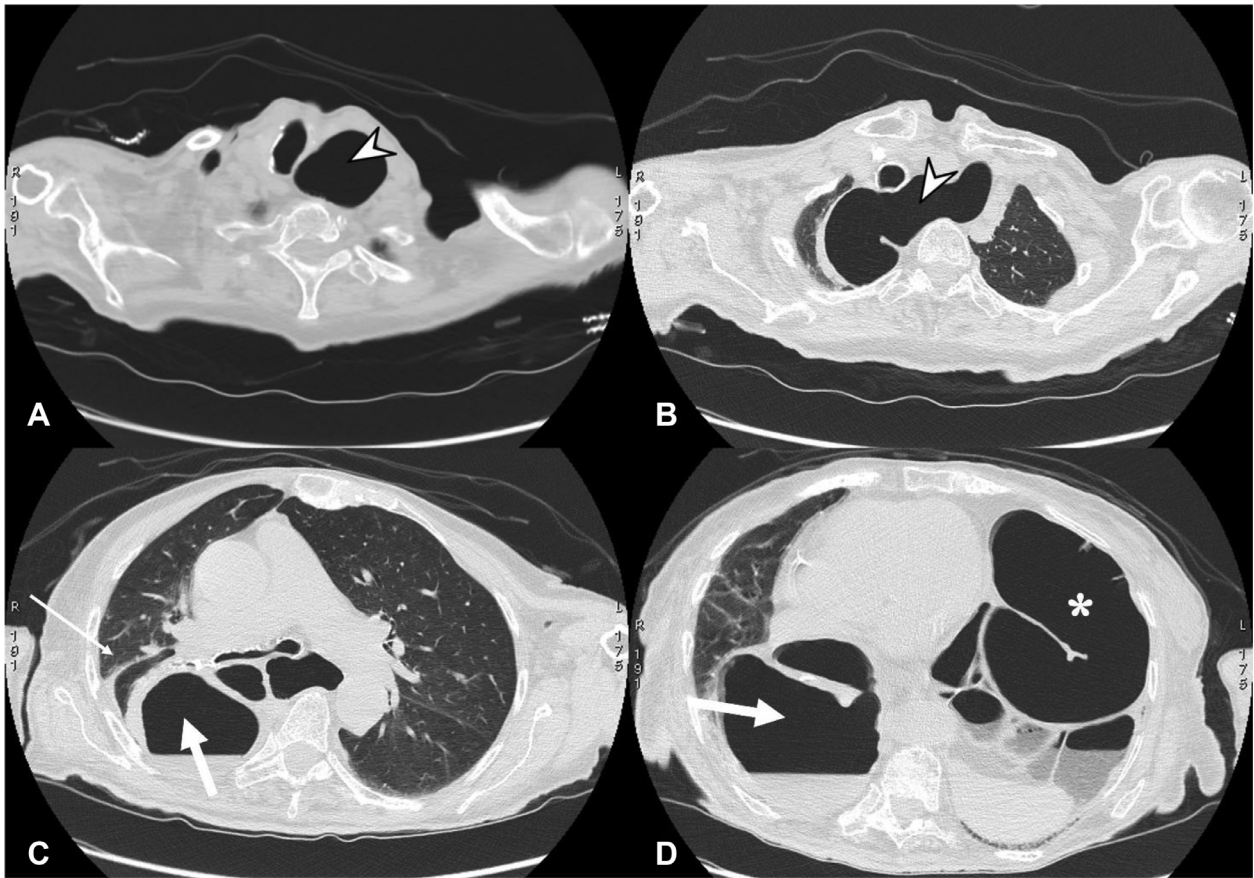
(A-D) Axial thoracic nonenhanced CT. Consecutive cranio-caudal axial scans obtained on lung window showing esophageal (arrowheads in A, B), gastric (thick arrow in C, D) and large bowel (asterisk in D) dilatation, with subsequent partial right pulmonary atelectasis (thin arrow in C).
